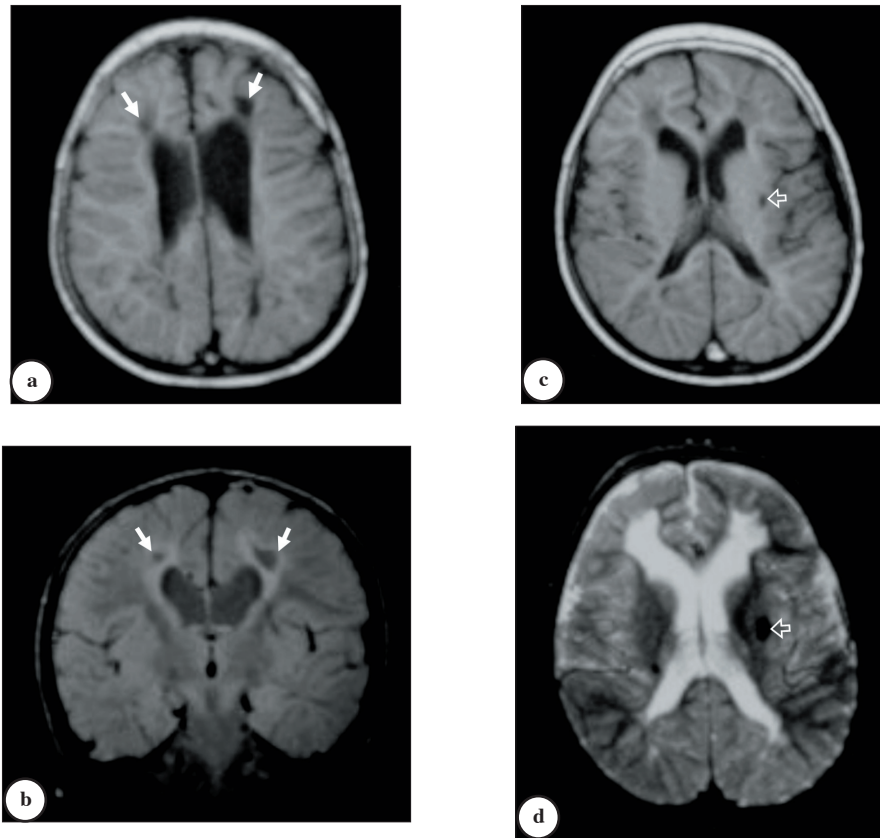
a) Axial T1-weighted (T1W) and b) coronal proton density-weighted MR images of the brain of a child with cystic leukomalacia (arrows) due to prior ischemic insult. c) Axial T1W image and d) T2W (spin-echo) image showing focal area of hemosiderin deposition (open arrow) in the region of left basal ganglia. Note that the lesion appears larger on T2W image due to magnetic susceptibility effect.
